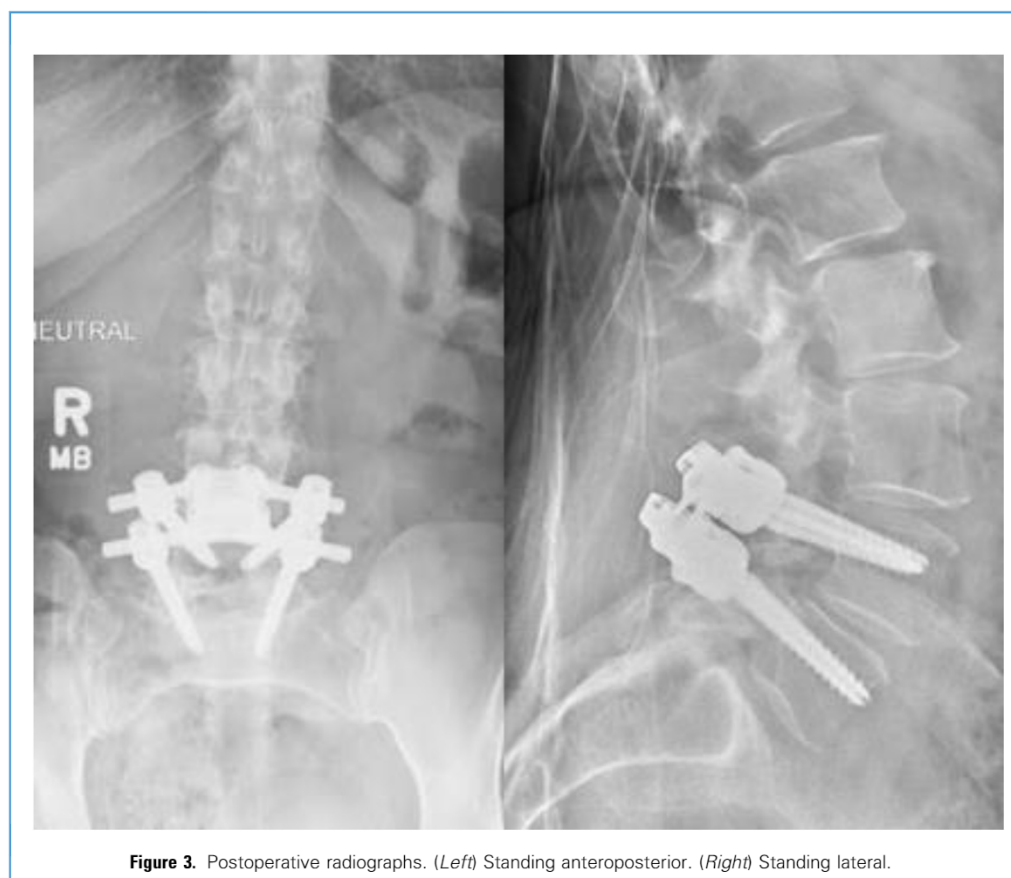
Postoperative radiographs. (Left) Standing anteroposterior. (Right) Standing lateral.
